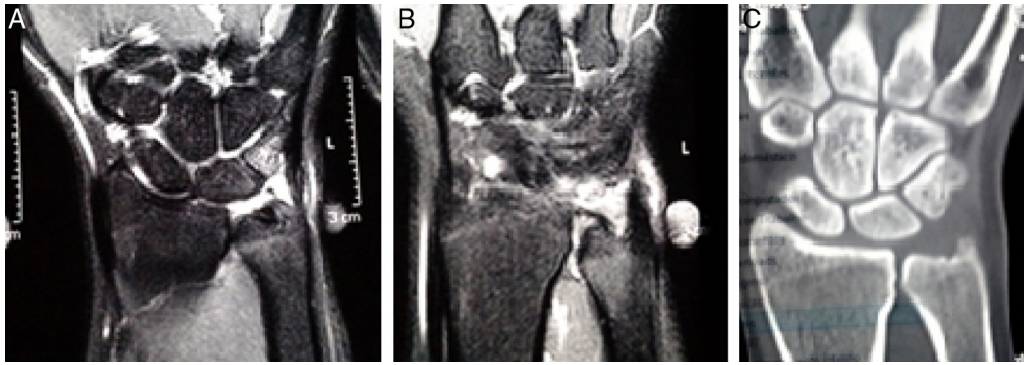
Images of case 1. (A) MRI evidencing synovitis and semilunar and pyramidal edema; (B) lesion of the triangular fibrocartilage in the distal portion only; and (C) tomography demonstrating neutral ulna.
